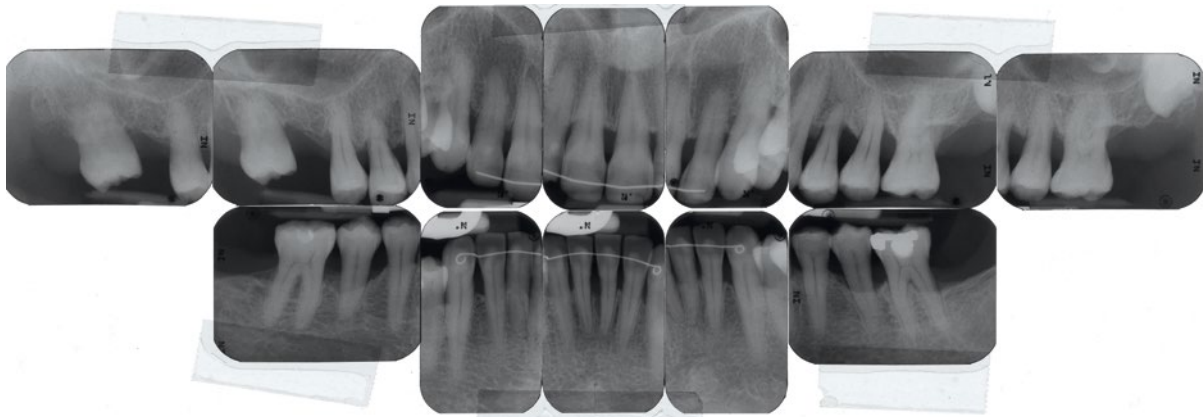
Periapical radiographs
